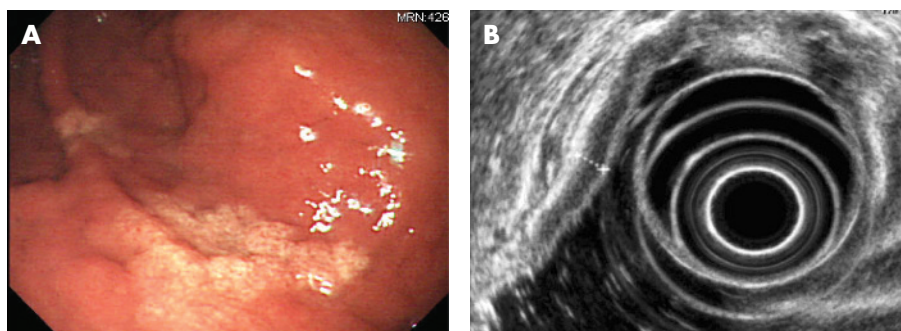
(A) Endoscopic view of patient 2. A yellowish nodular raised lesion was seen on the anterior wall of the lower body. (B) Endoscopic ultrasonographic finding of patient 2. Thickened mucosal layer without submucosal invasion was seen.
